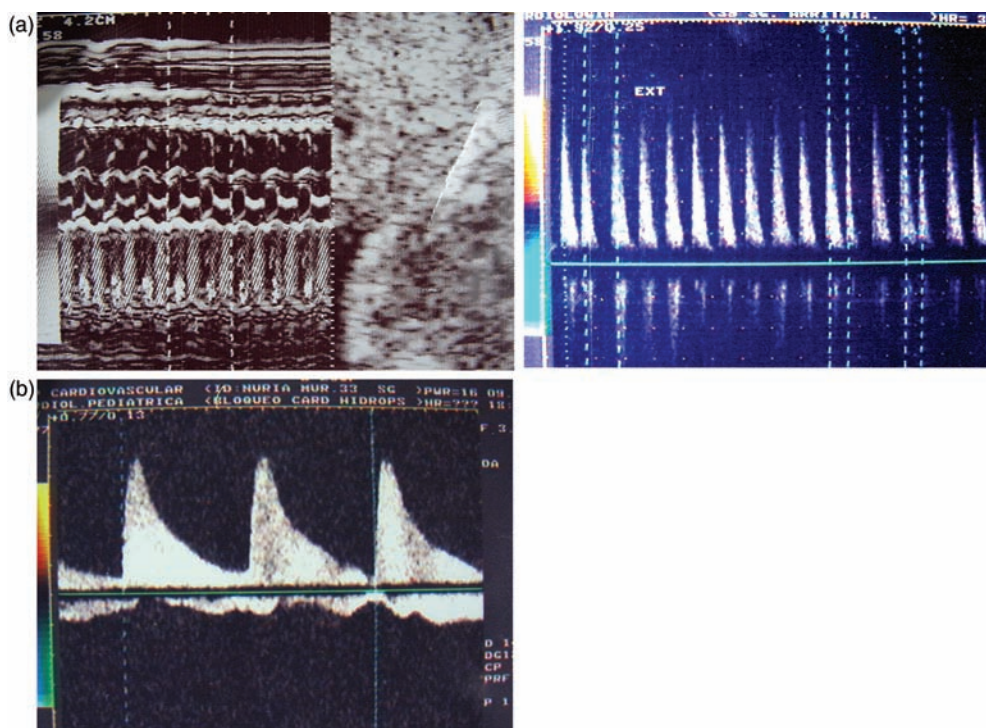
(a) Supraventricular tachycardia using M-mode echocardiography to establish a 2/1 atrioventricular rate comparing the atrial wall movements and the aortic valve opening. (b) Ventricular bradycardia in a congenital complete A–V block.
